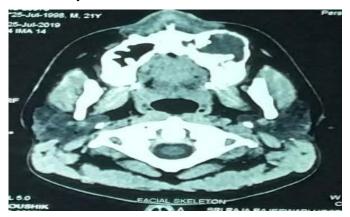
Computed Tomography images showing hypo dense lesion occluding the left maxillary sinus.
